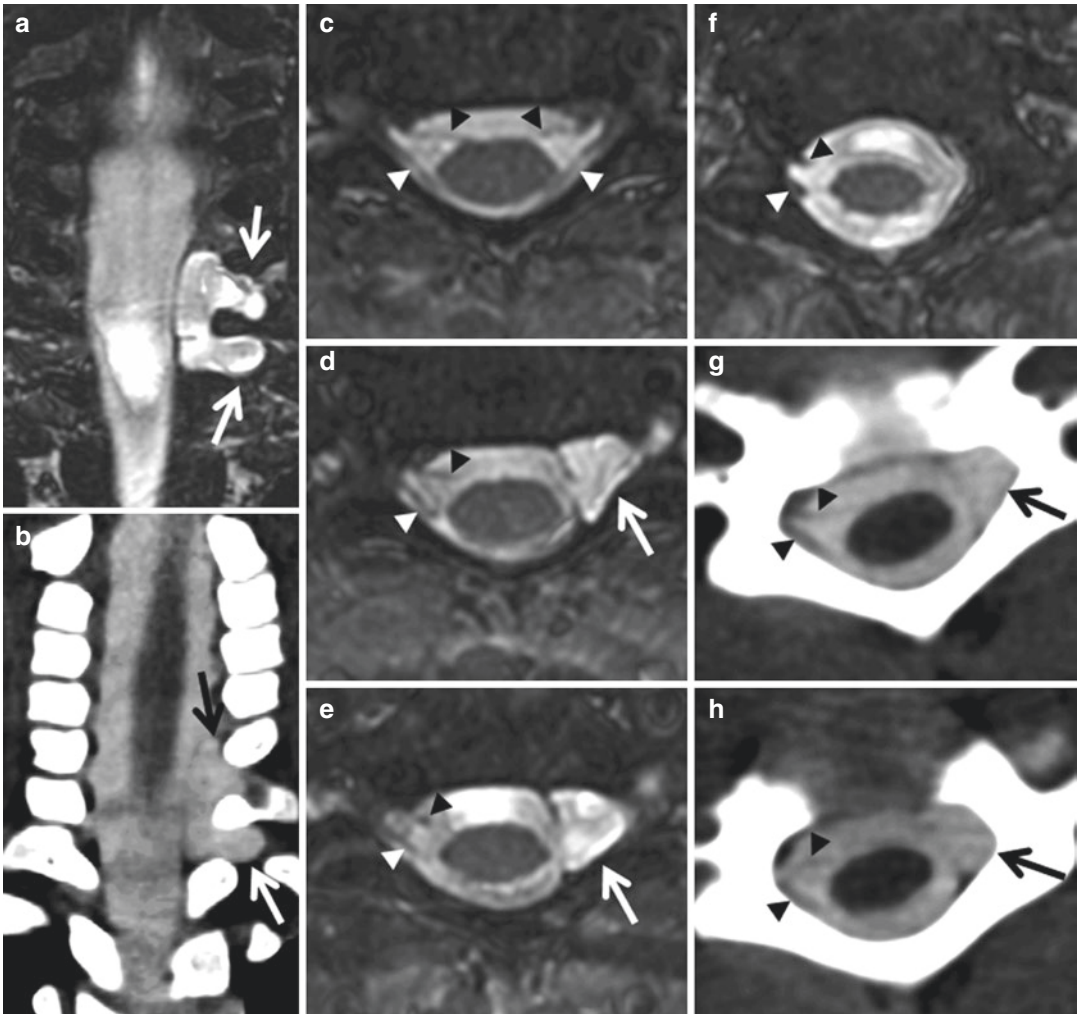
Complete ventral and dorsal nerve root avulsions and pseudomeningoceles in a 7 month-old male. Heavily T2-weighted three-dimensional gradient echo MR images, FIESTA sequence (GE) (a, c–f) and CTM (b, g, h) in the coronal (a, b) and axial (c–h) planes. Axial images are at the normal C5–C6 level (c) and at the abnormal C6–C7 (d, g), C7–T1 (e, h), and T1–T2 (f) levels. Communicating left C6–C7 and C7–T1 pseudomeningoceles are readily seen on both modalities (arrows in a, b, d, e, g, h), with mild deformation of the left lateral aspect of the thecal sac. The presence/absence of nerve roots is
